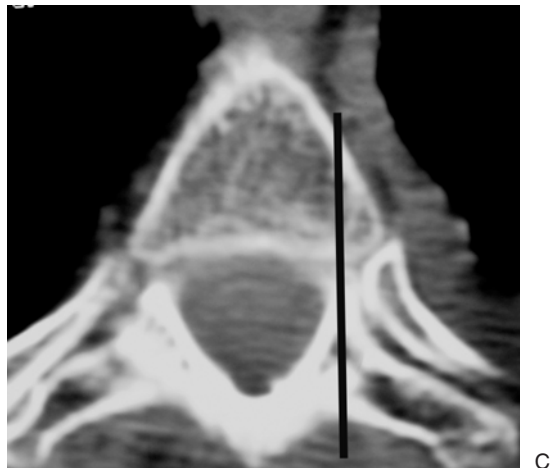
(A) A lateral radiograph after PV demonstrates the apparent anterior and posterior vertebral margins (black arrowheads). Cement in the back of the vertebra (white arrow) appears to stop before reaching the posterior vertebral margin. (B) Computed tomography scan of the same vertebra as in A. Note the concave posterior margin of the vertebra and the small cement leak (white arrow). The actual vertebral margin ends before the apparent margin as seen on the lateral radiograph. Cement injection should be stopped when cement enters the posterior quarter of the vertebra. (C) An axial CT scan of a thoracic vertebra demonstrates its very convex anterior margin. The black line depicts a straight transpedicular approach. Note that this approach would breach the anterior cortex long before the needle reaches the apparent anterior margin when seen in the lateral projection.
